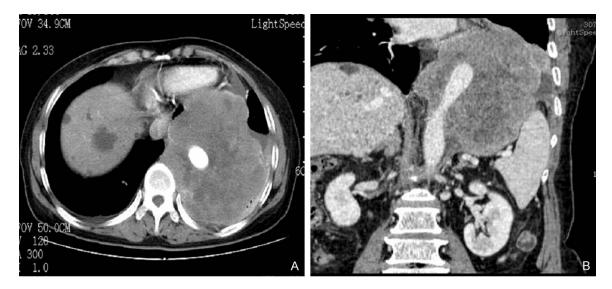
Large soft-tissue mass in left lower chest; after enhancement, patchy necrotic area wrap around aorta descendens and indistinct development were discovered. (A: Computed tomography (CT) enhancement; B: Coronal recombination).
